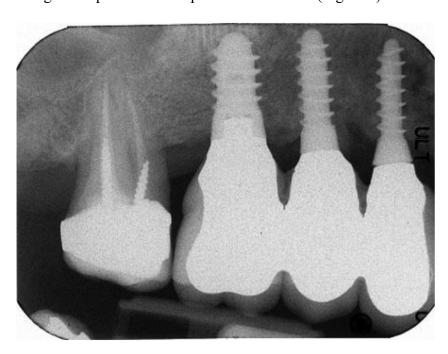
Periapical Rx 1 year after implant placement.
